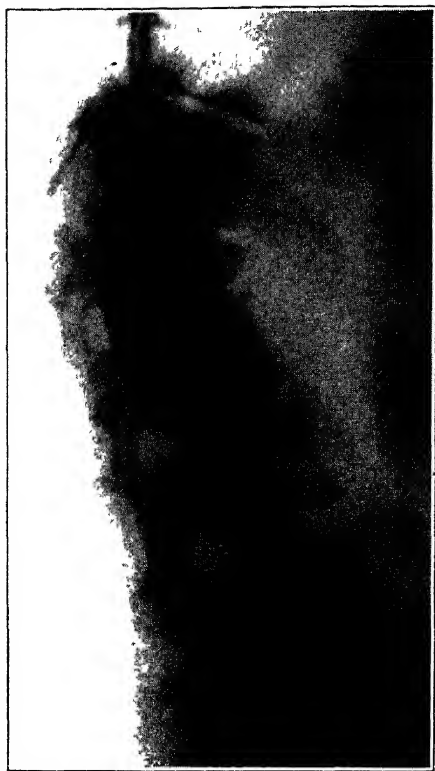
Case 3 Roentgenogram on admission, showing fracture dislocation of the eleventh and twelfth thoracic vertebrae (Courtesy, Journal of Bone and Joint Surgery, July, 1938)
